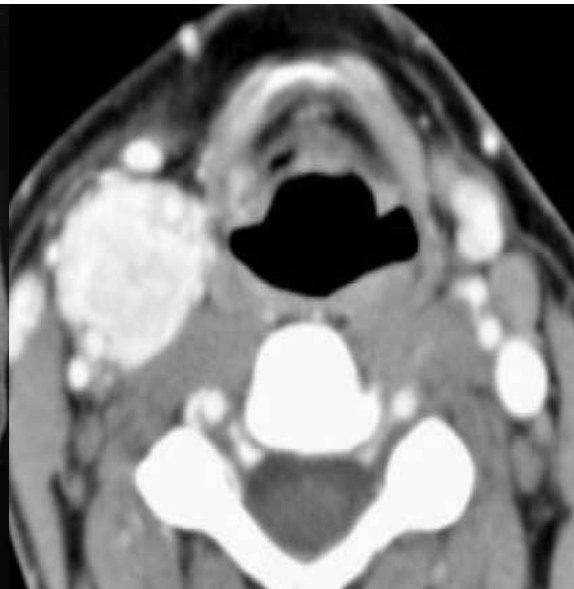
Paraganglioma on contrasted CT in Carotid space
